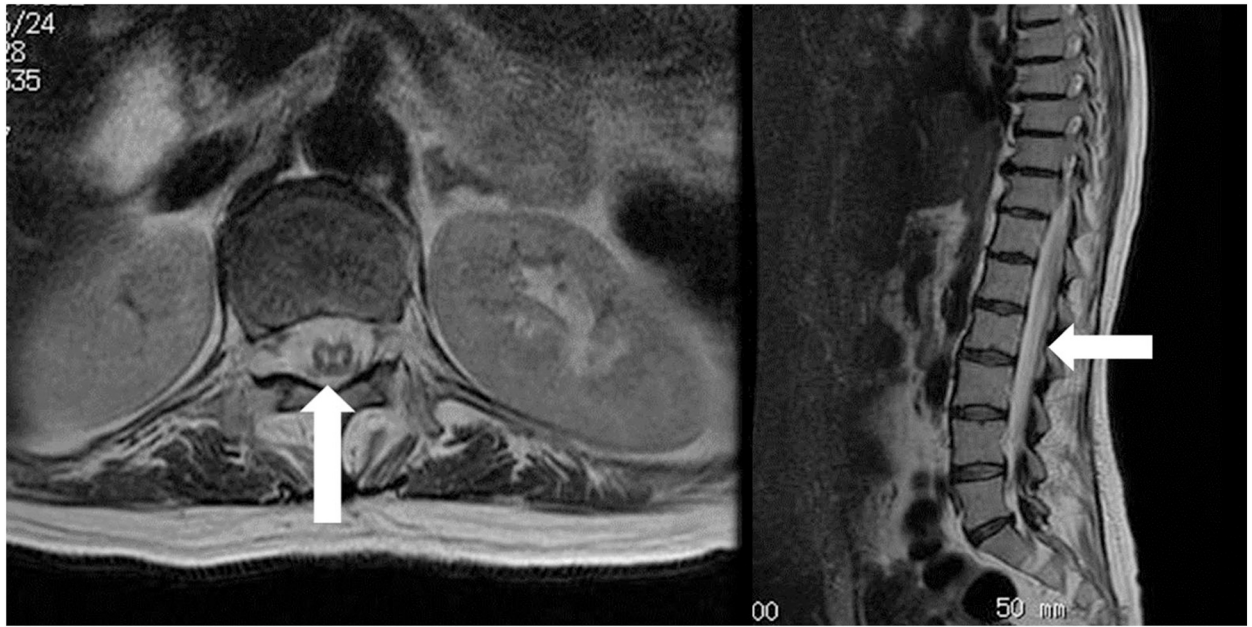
MRI images taken 14 days after admission under the same protocol as in Fig. 2. No changes were noted.
